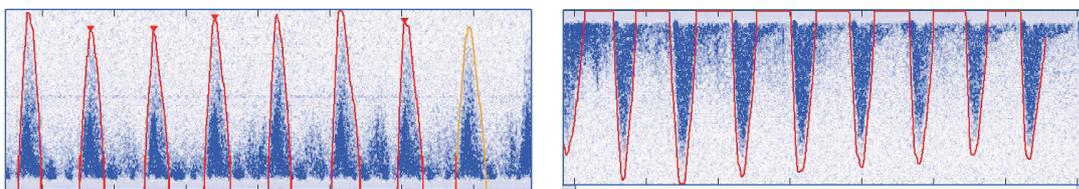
Examples of Doppler flow profiles. Left: a positive Doppler shift for the Aortic Valve, right: a negative Doppler shift for the Pulmonary valve.
